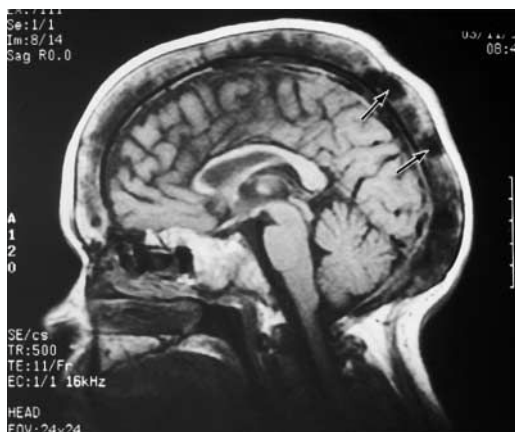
Sagittal T₁-weighted MR image revealing diffuse calvarial thickening. The hypointense areas in the marrow spaces represent areas of hypererythropoiesis or so-called brown tumors (arrows).
